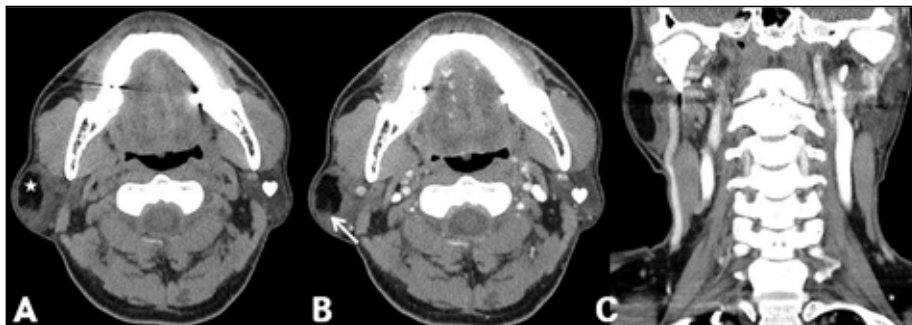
On CT images, a well-defined, low-density mass (asterisk) was about 1.6 x 2.7 x 2.9 cm with multiple patchy high density in the peripheral portion (white arrow) without significant enhancement in the right parotid gland. The mass originated from the superficial lobe of the parotid gland. The normal parotid gland around the tumor was not compressed or displaced by the lipoma and the subcutaneous fat layer was relatively well preserved. A. non-enhanced axial, B. enhanced axial, C. enhanced coronal, heart shape: normal left parotid gland
